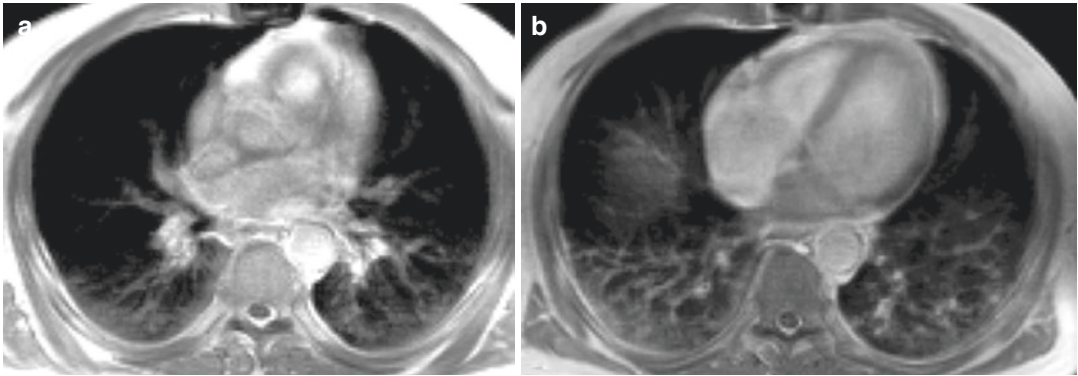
A 61-year-old male patient with interstitial lung disease associated with rheumatoid arthritis, with MR findings suggestive of nonspecific interstitial pneumonia. Post-contrast T1-weighted 3D FLASH axial images
